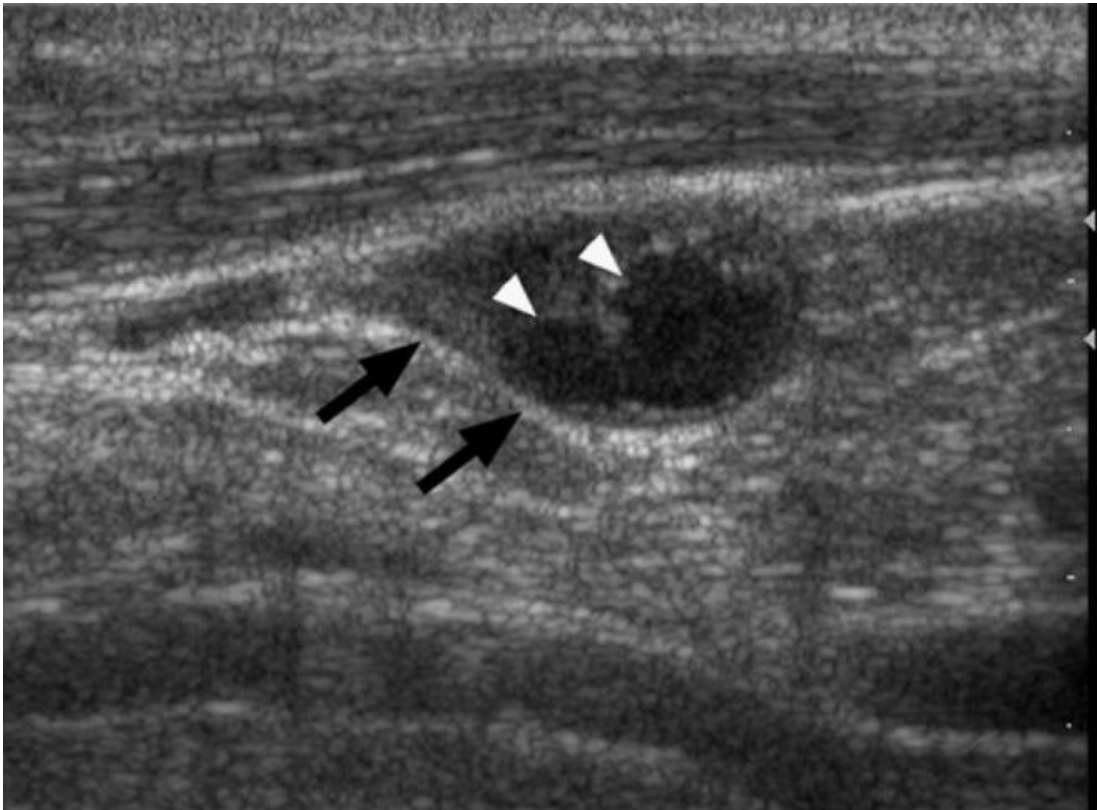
Ultrasonography of tubercular lymphadenopathy
